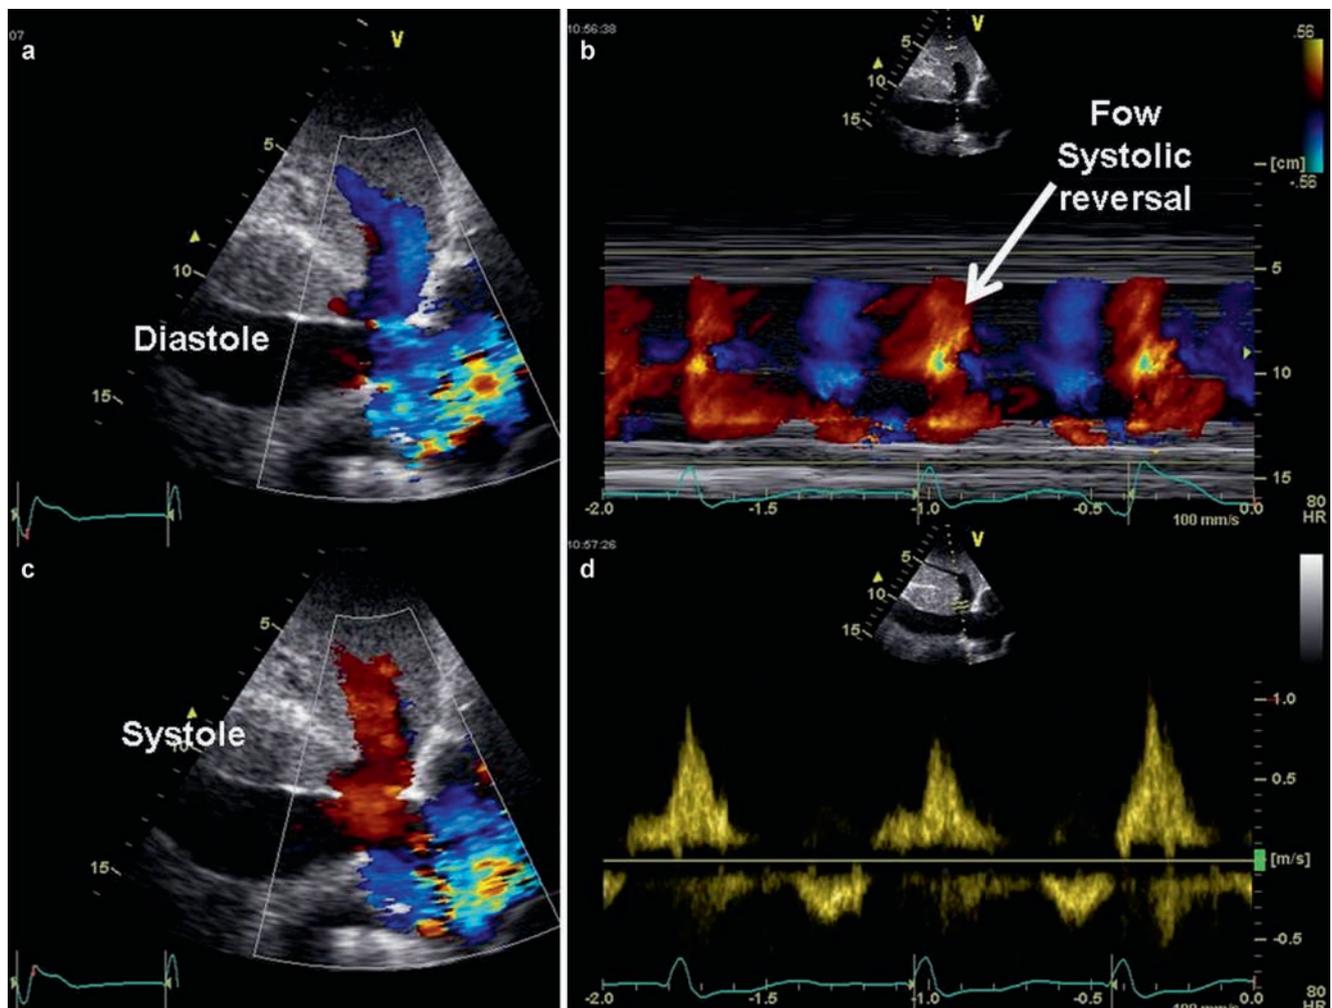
Sub-costal echocardiogram recorded in a patient with severe TR. (a–c) The colour Doppler confirms retrograde flow into the vena cava and hepatic vein in systole consistent with TR (red). (d) A
